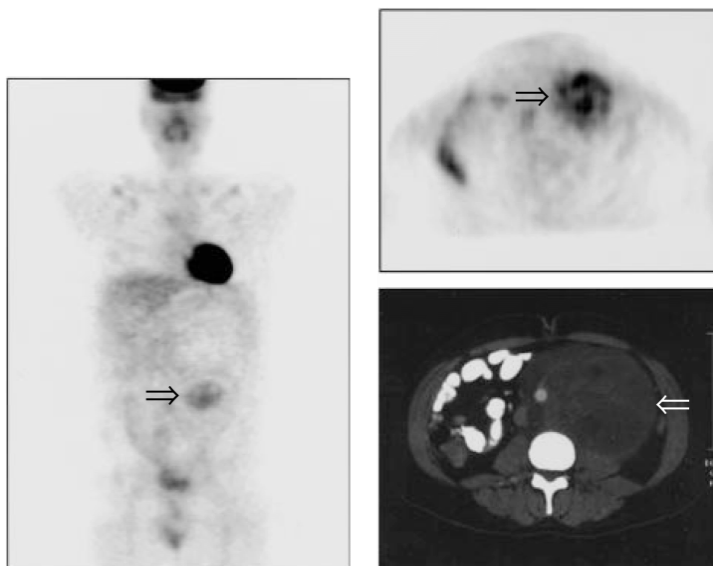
PET image (coronal and axial) and CT (axial) of post-chemotherapy residual mass. PET scan reveals focus of FDG uptake (arrow). Pathologic examination revealed teratocarcinoma.
